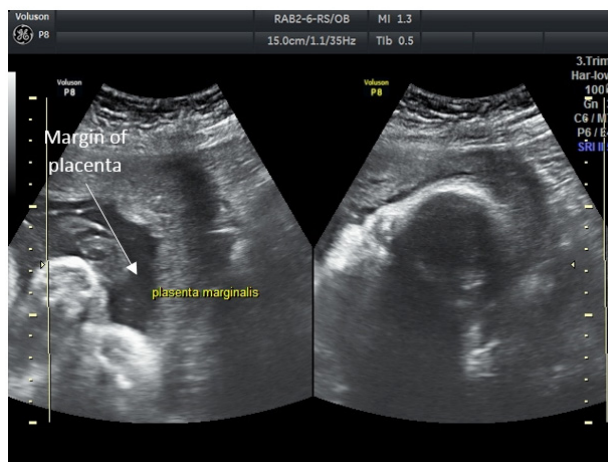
Marginal Placenta Previa on Ultrasonography Examination
